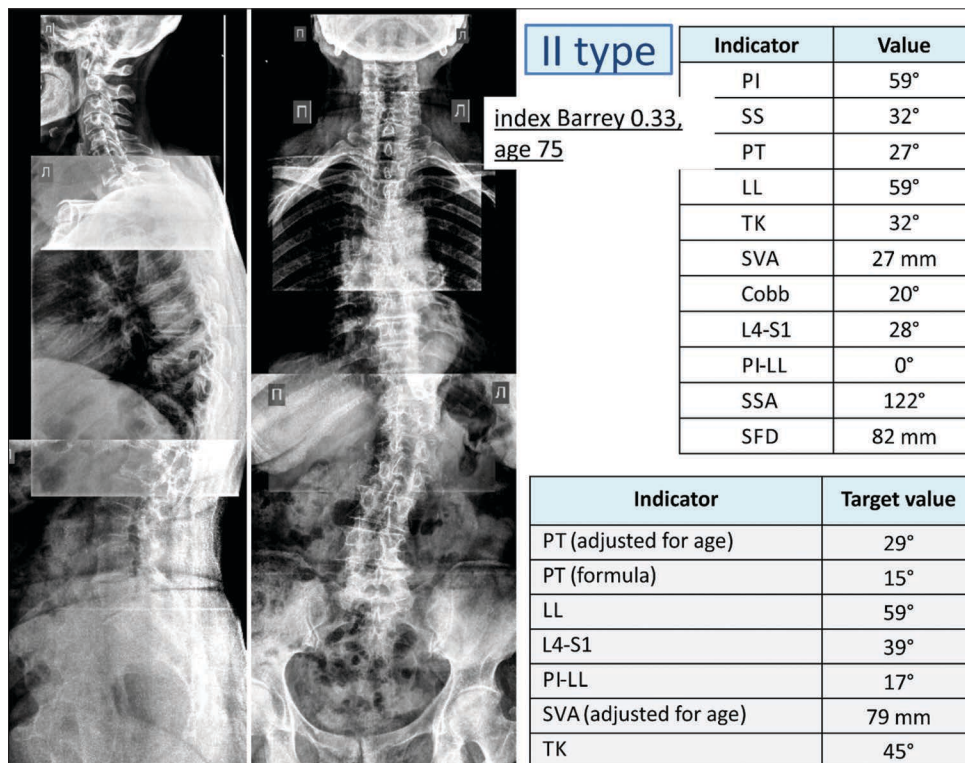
X-ray of a 75-year-old patient with adult degenerative scoliosis, compensated frontal and sagittal imbalance, Index Barrey–0.33
